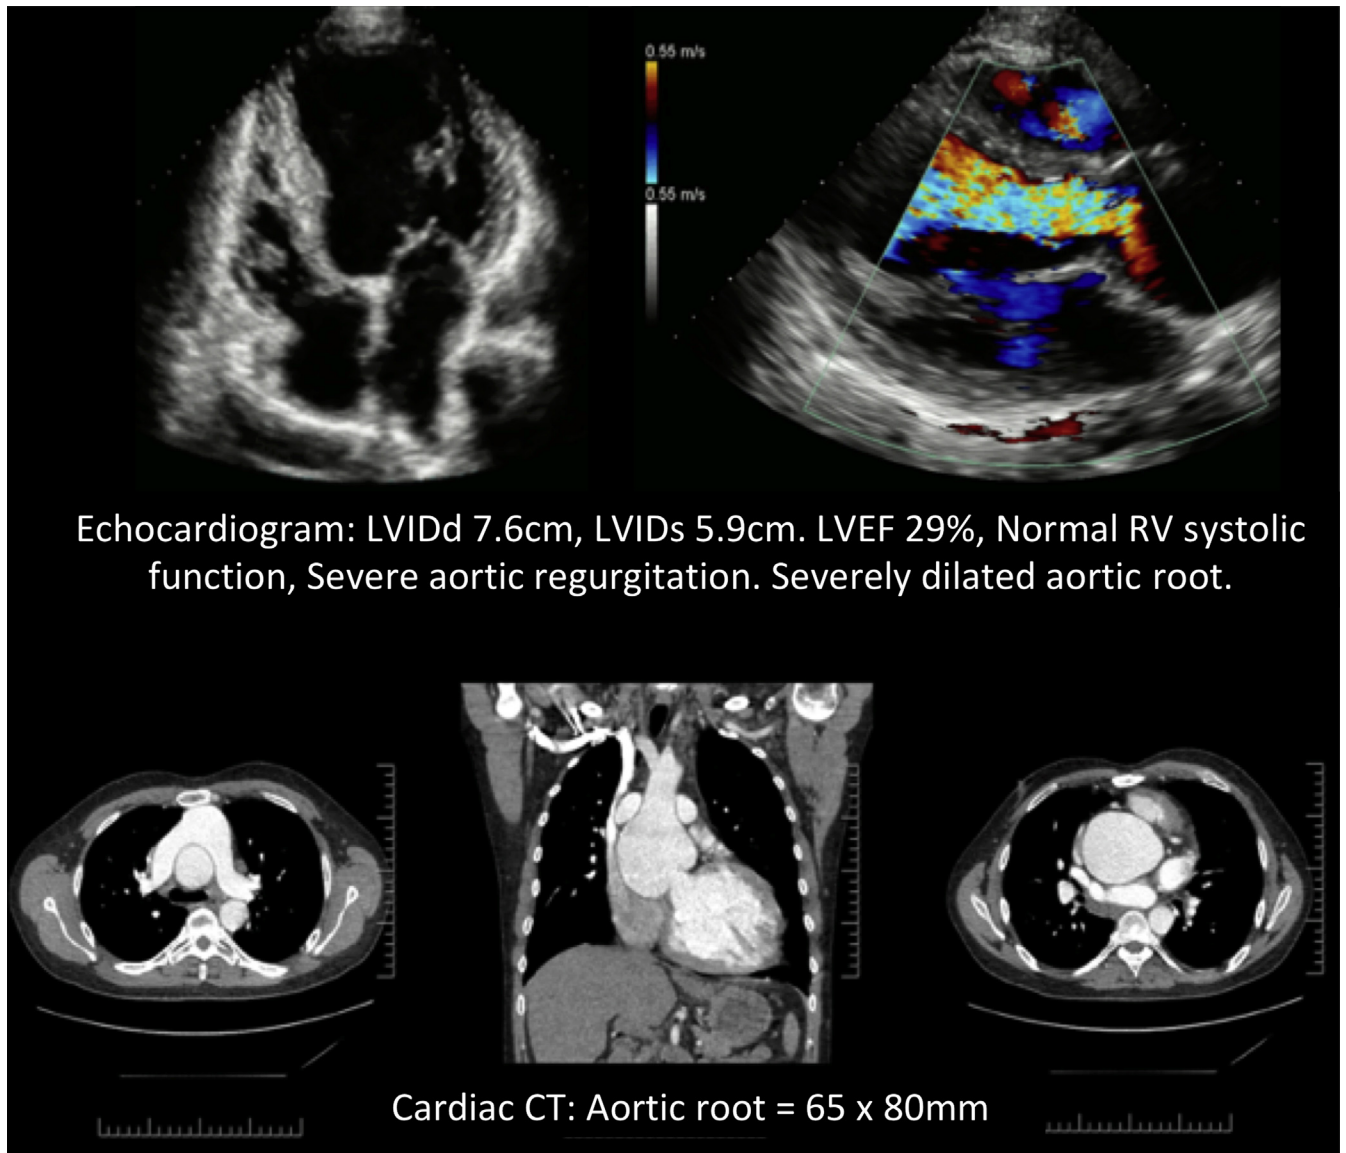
Imaging assessment of case study 1. CT, computed tomography; LVEF, left ventricular ejection fraction; LVID, left ventricular internal dimension; RV, right ventricle.
